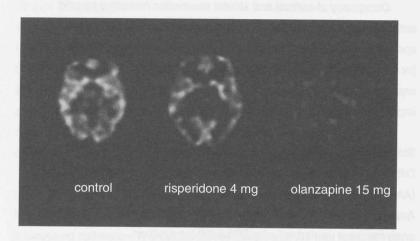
[<sup>123</sup>]-IDEX SPECT transversal slices at the level of the striatum of one patient treated with olanzapine 15 mg, one with risperidone 4 mg and a control subject. [<sup>123</sup>]-IDEX binding in the striatum and cortex of the patient with olanzapine is lower than in the control, reflecting a higher level of muscarinic receptor occupancy. Colour version on the inside of the cover.
